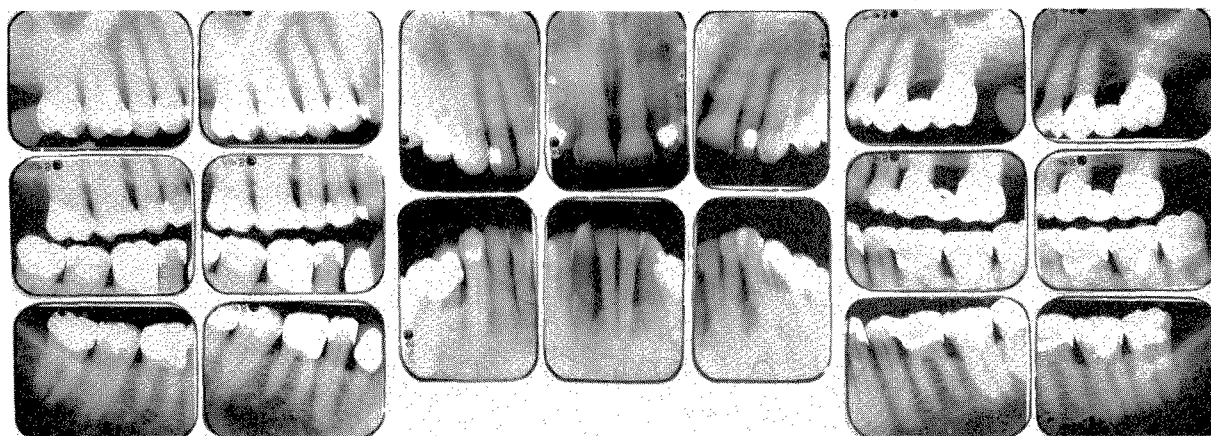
Roentgenograms taken in September, 1961. Although extensive gum recession was evident, the bone structure was in excellent condition. This patient had always been subject to an unusual amount of recession as seen in Fig. 59.
